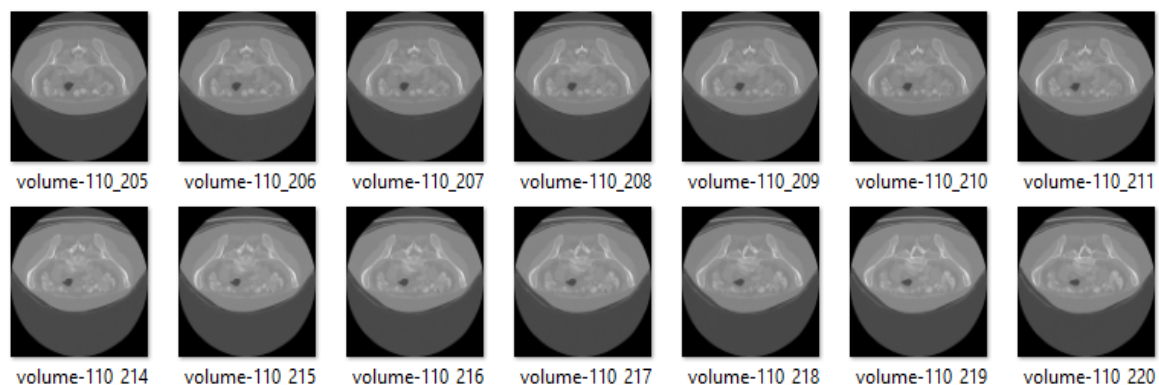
Sample liver CT images from dataset
